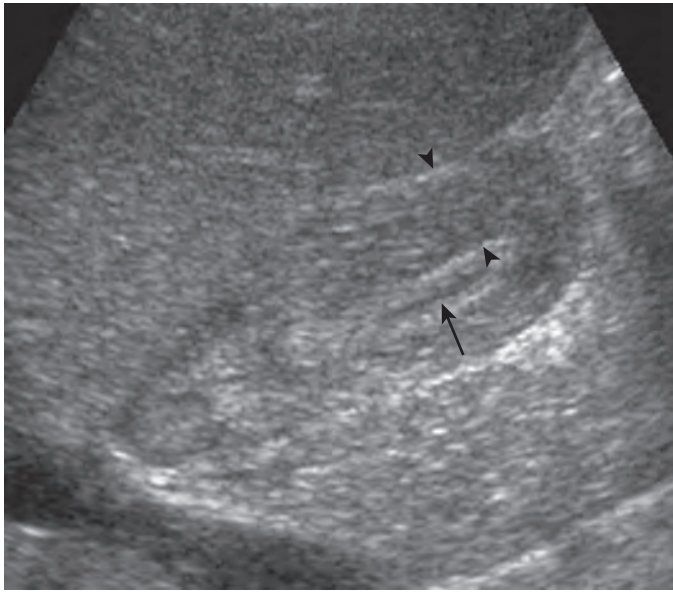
Acute acalculous cholecystitis: sonographic findings. The gallbladder wall is diffusely thickened (arrowheads). The tiny, hypoechoic lumen is free of stones (arrow).
